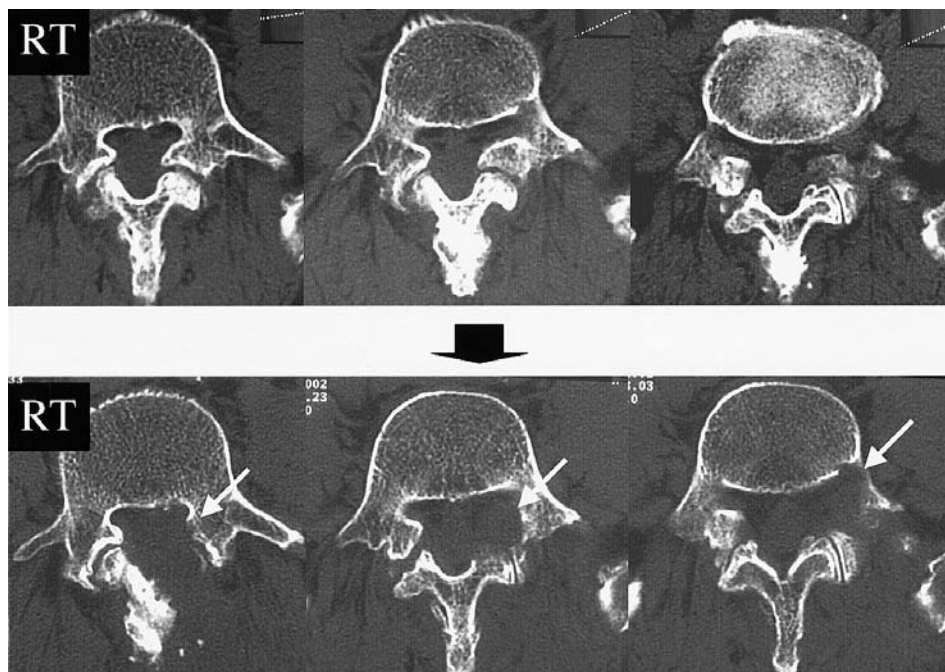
Case 5. Axial CT scans obtained before (upper) and after operation (lower). White arrows (lower) indicate the site to be decompressed.
